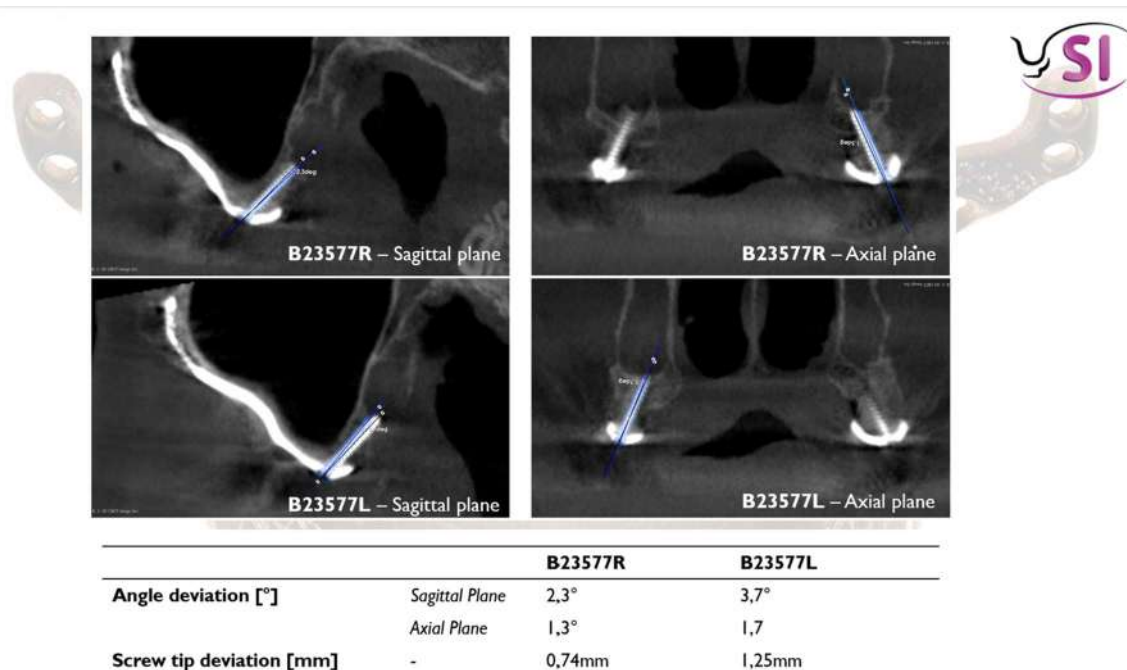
Sagittal and axial CBCT views show the superimposition of the planned (blue) and actual postoperative screw positions on the right (B23577R) and left (B23577L) sides. Angular deviations ranged from 1.3° to 3.7°, while screw tip deviations remained below 1.5 mm, demonstrating the high accuracy and reproducibility of the guided pterygoid anchorage protocol.
